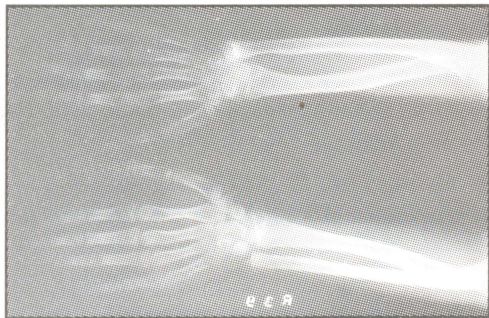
X-ray both wrists showing Madelung deformity on left side.
